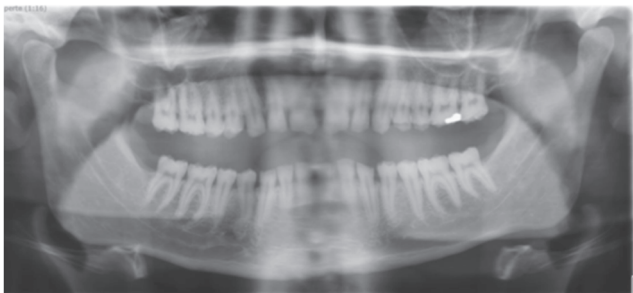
Son's orthopantomogram. First consult. Enamel is less opaque than dentin. Left condyle is in anteriorly position
